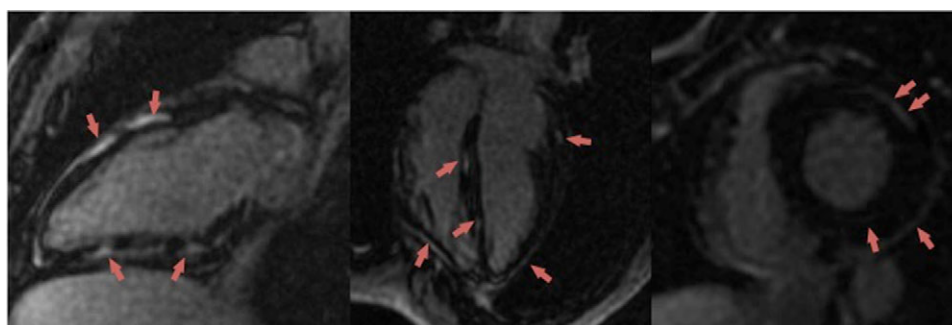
Cardiac MRI showing extensive epicardial and myocardial enhancement in delay post-contrast images consistent with myocarditis.
